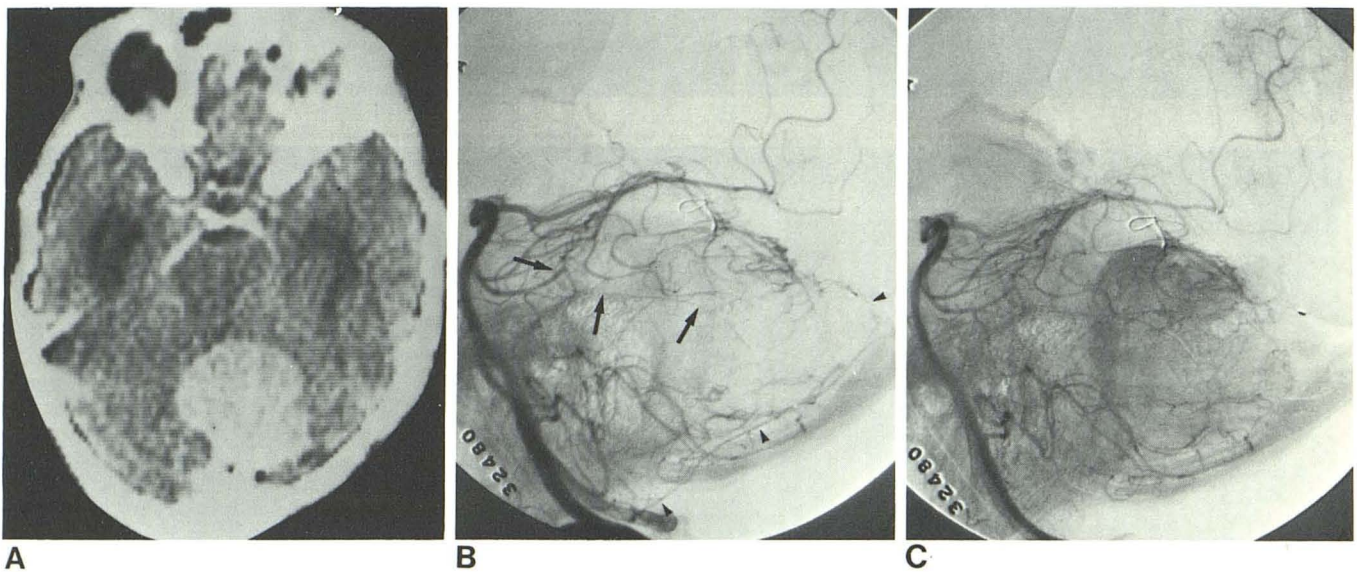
Case 1. Tentorial recurrence posterior fossa. A, Enhanced CT scan. B, Left vertebral angiogram, early arterial phase. Enlargement of posterior meningeal artery (*arrowheads*) which supplies periphery of tumor posterosuperiorly, while branches of superior cerebellar artery (*arrows*) supply tumor "capsule" anteriorly. C and D, Left vertebral angiogram, late arterial phase. Tumor blush. No early draining veins.
